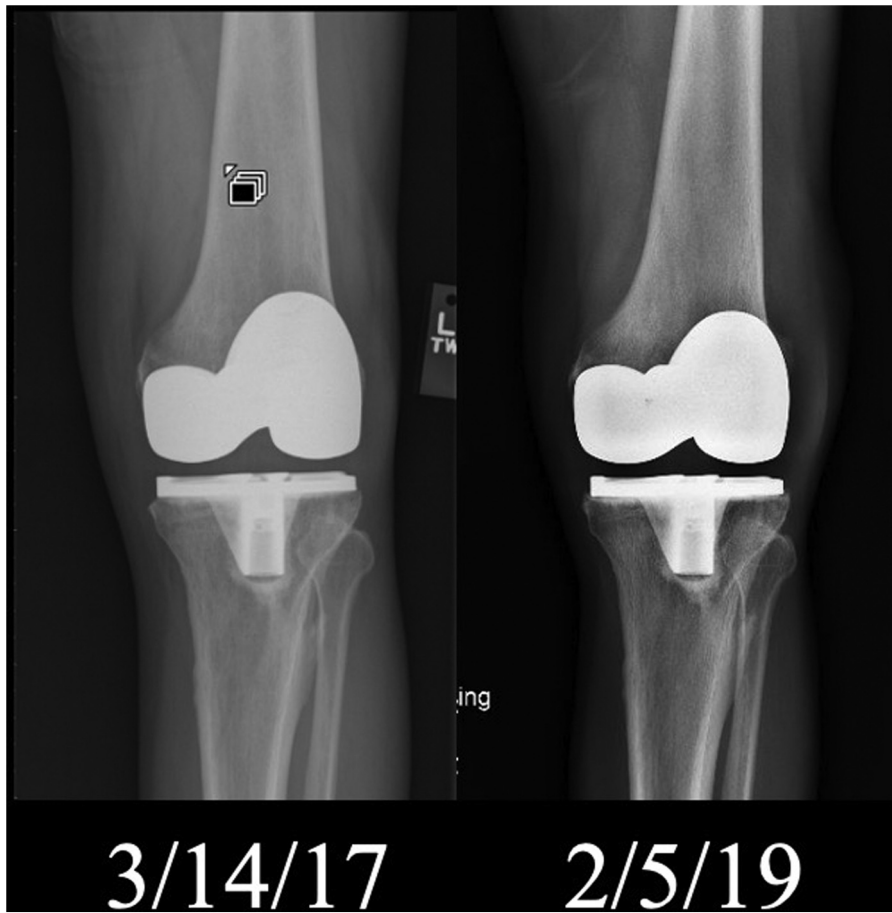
Anteroposterior radiograph of the left knee from post op (3/14/17) and 2 year follow up (2/5/19) after primary total knee arthroplasty.
